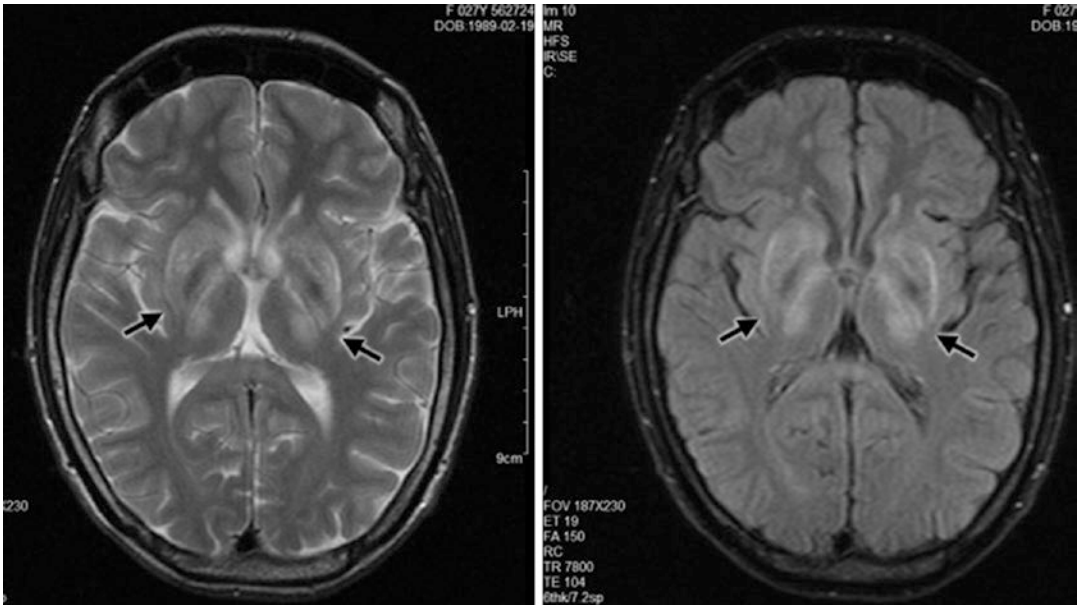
Magnetic resonance imaging (MRI) of the brain in the patient. Axial MRI exhibits hyperintensity (arrows) in the bilateral lenticular nuclei and thalami on
